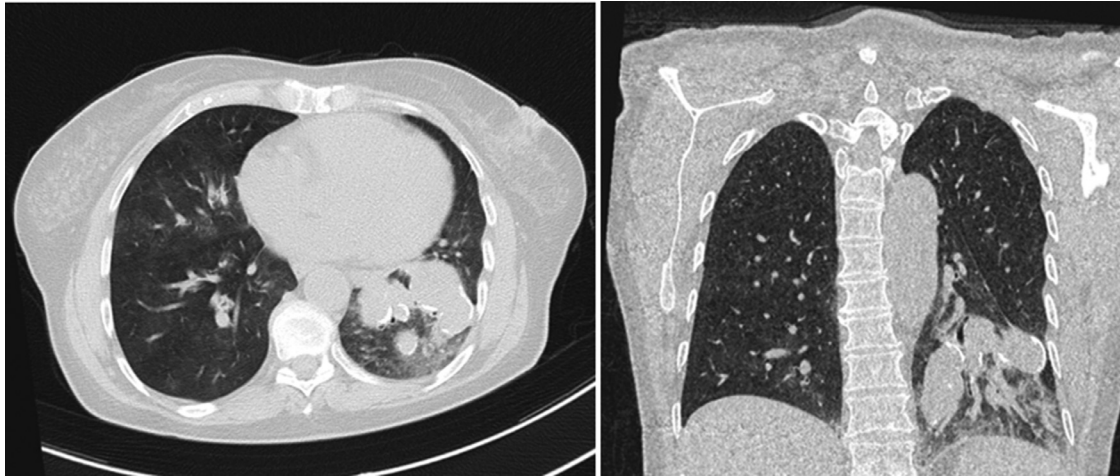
Axial and coronal computed tomography (lung window) shows a left lower lobe mass with peripheral calcifications, associated with adjacent ground-glass opacities, suggesting alveolar hemorrhage.
